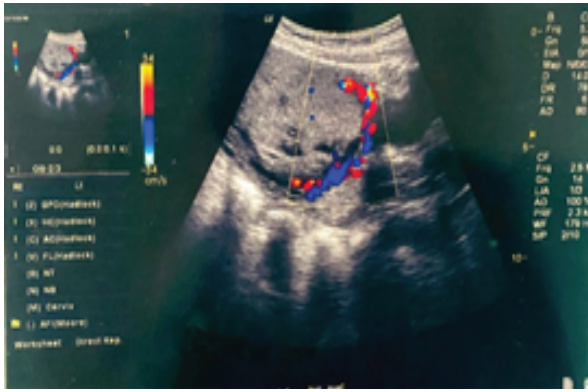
Ultrasound images antenatally showed placenta previa, diffuse placenta accreta spectrum on the lower anterior uterine wall.
